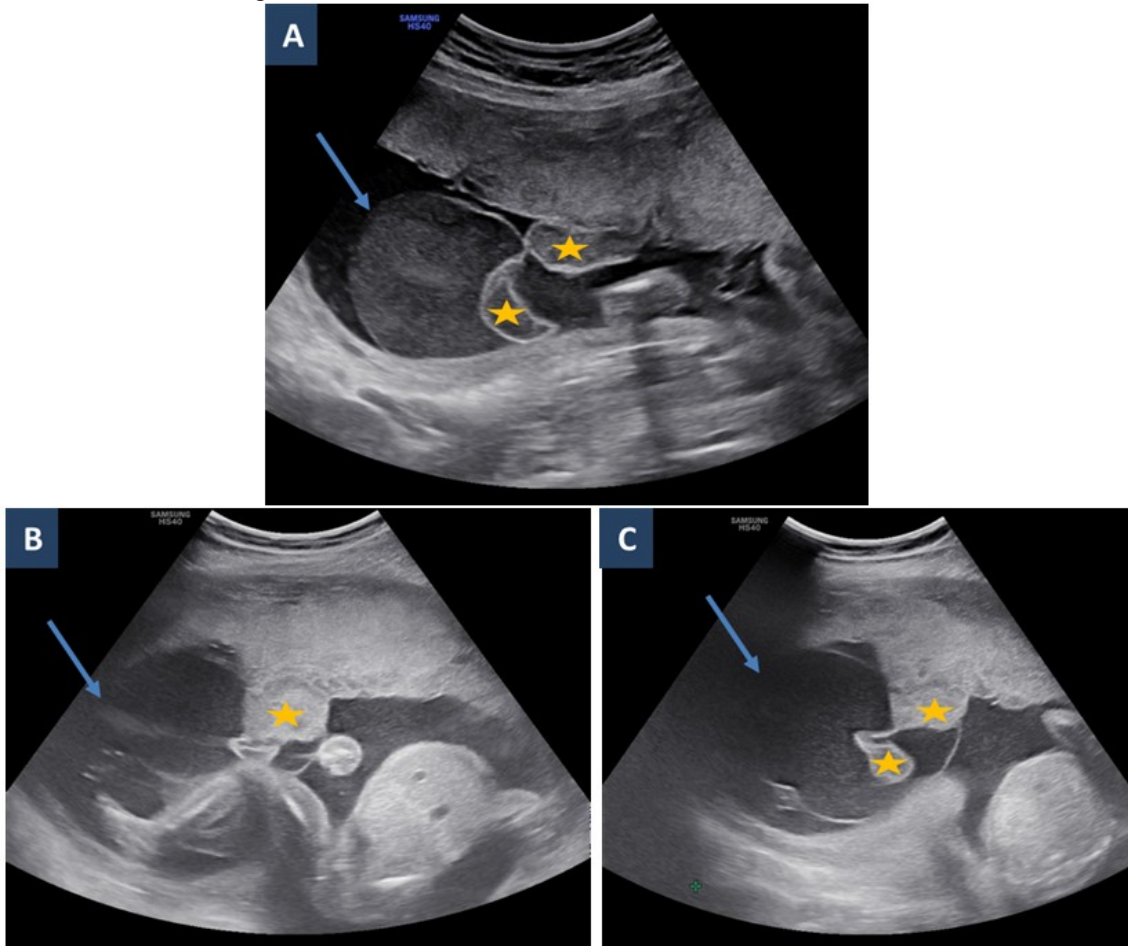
Ultrasound images showing the anatomical features that form a subamniotic hematoma, evolving on the fetal side of the placenta: (A) at 20 weeks and (B), (C) at 28 weeks of gestation in the same patient. Note a cystic formation protruding from the chorionic plate, thin-walled (arrows) and hypoechogenic content, with two inert formations, one floating, and the other still attached to the chorionic plate, corresponding to organized clots (stars).
